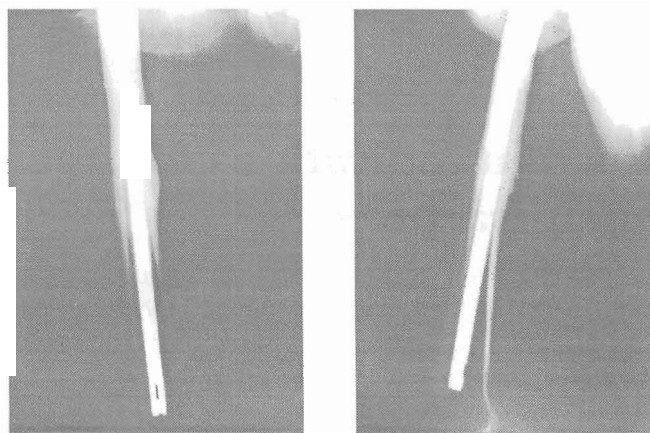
Same patient (as in Fig 1) radiographs 3 months after operation showing sound union of the fracture in good position, (a) anterior-posterior, (b) lateral views.
